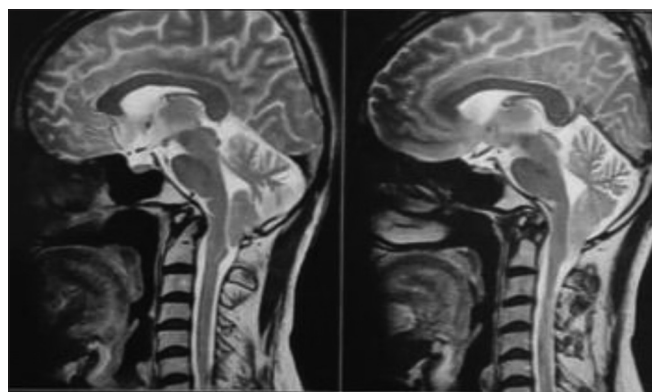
Preoperative magnetic resonance imaging craniovertebral junction with Chiari malformation-1 without syrinx
